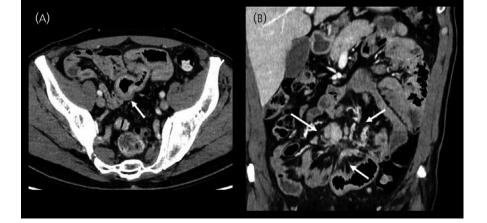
Transverse computed tomography images on portal phase in transverse (A) with coronal reconstruction (B) show a desmoplastic reaction of the mesentery (three arrows) and signs of ischemia, including vascular ectasia, bowel wall thickening with enhancement and target appearance (arrow)
